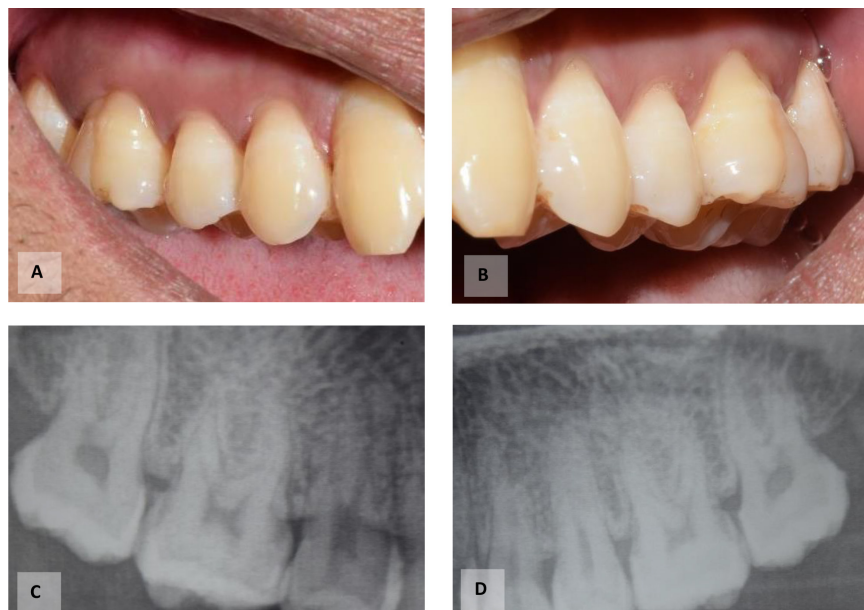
Test and control sites (16 and 26, respectively) with Miller's class I gingival recession and DH. (A) and (C) Clinical and radiographic picture of the test site; (B) and (D) Clinical and radiographic picture of the control site.
